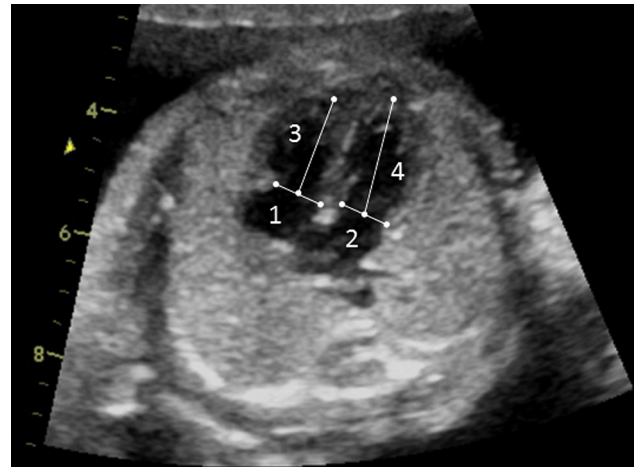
Apical four-chamber view of the fetal heart showing measurement of the (1) tricuspid valve annulus, (2) mitral valve annulus, (3) right ventricular length, and (4) left ventricular length.
